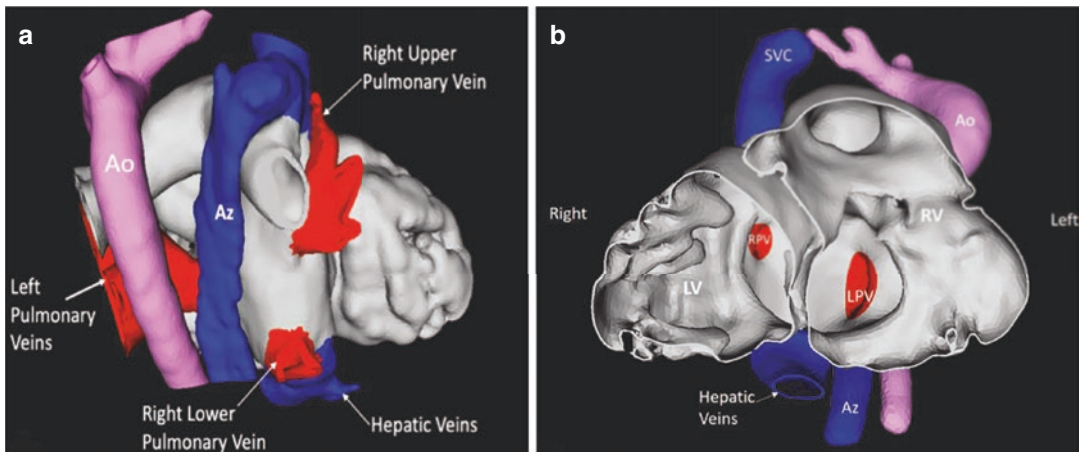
3D virtual model created from cardiac MRI. Three-year-old with heterotaxy syndrome, interrupted inferior vena cava with azygous continuation, ipsilateral pulmonary vein drainage, and L-looped ventricle orientation (left ventricle to the right of morphologic right ventricle). (a) Posterior view showing both right pulmonary veins and the systemic veins draining to the right atrium. The left pulmonary veins drain normally to the left atrium. (b)
